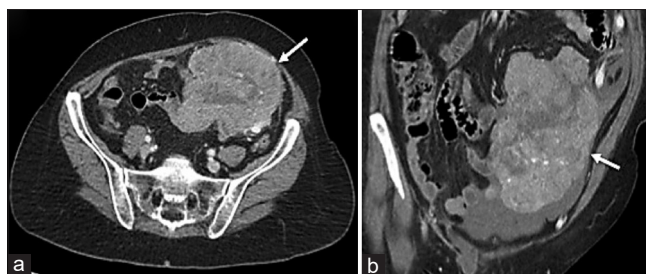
Axial (a) and coronal (b) computed tomography of the abdomen and pelvis with intravenous contrast demonstrating a solid, heterogeneously enhancing mass in the lower abdomen (arrows) suspicious for malignant neoplasm
